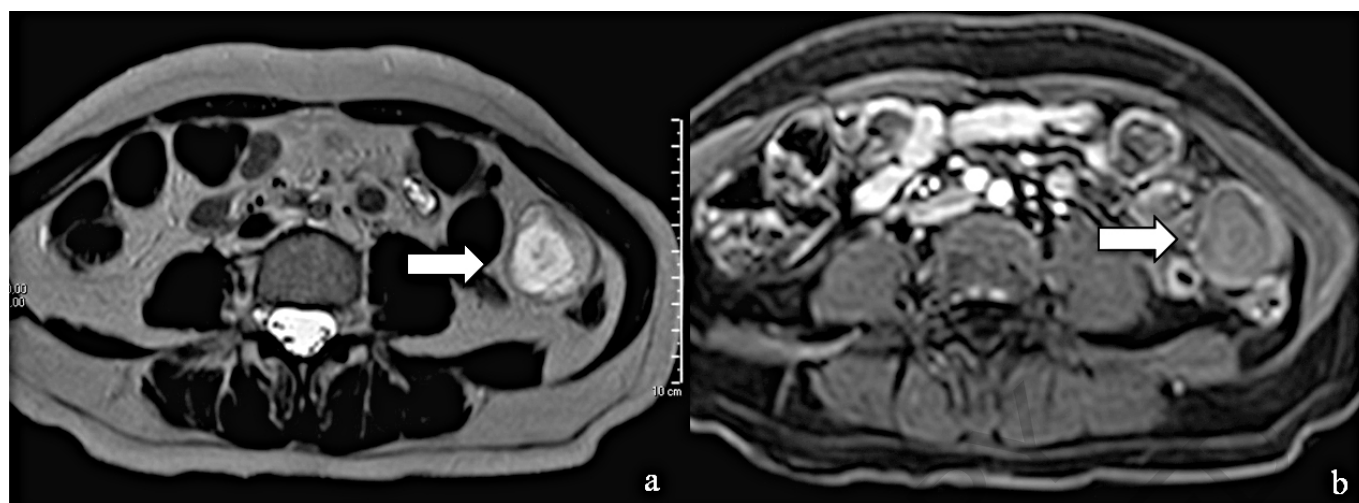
Endometrial stromal sarcoma extrauterine. Axial T2-weighted (a) and axial contrast enhanced T1 fat saturation (b) reveal a heterogeneous encapsulate mass with high signal on T2-weighted and peripheral contrast enhancement on fat saturated T1-weighted (arrows).
